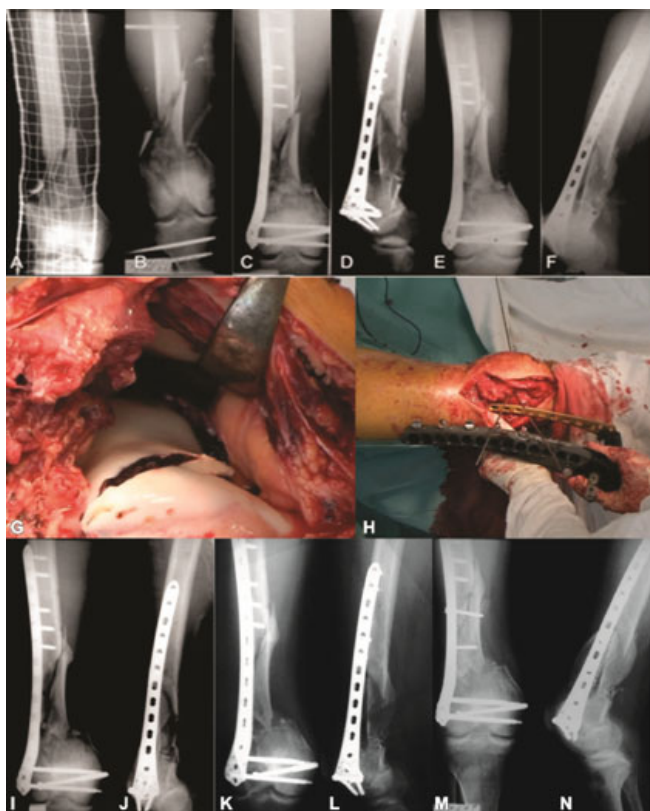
(A-N) Distal femoral fracture (type C3/AO) with bone loss and open type II Gustilo. (A) preoperative aspect (B) external temporary fixation in damage control period (C,D) Internal fixation with LCP-distal femur, postoperative control (E,F) Radiographic aspect at 1 month post-operatively (G,H) intraoperative aspects (I,J) 3 months postoperative (K,L) 5 months postoperative, delayed union (M,N) defect filled with Eurocer granules mixed with bone graft from iliac crest
